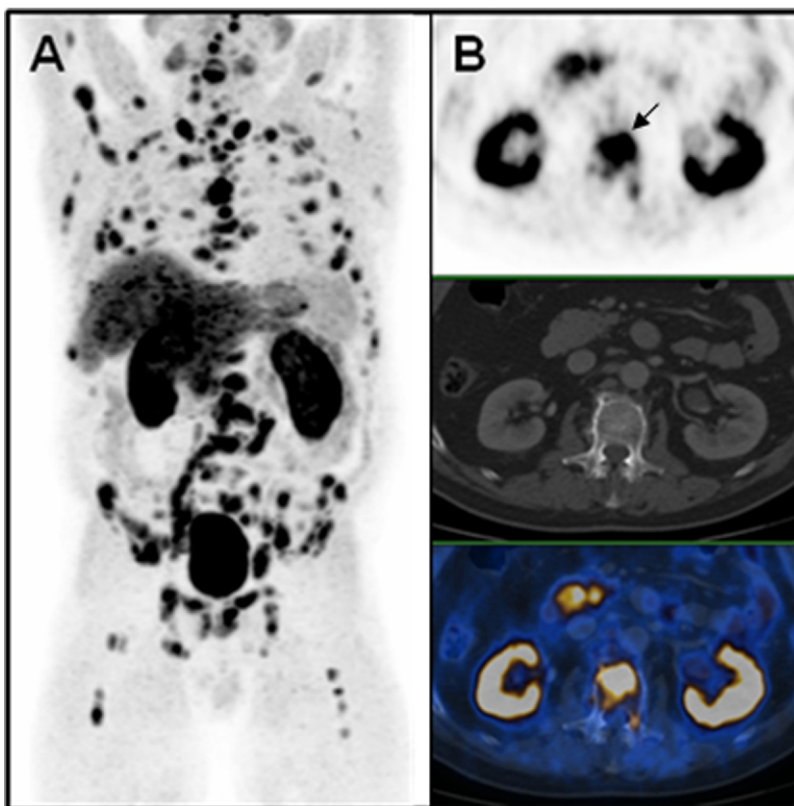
(A) Generalized BM detected by FCH PET/CT (MIP-Image) from a high-risk prostate cancer patient. (B) Transaxial images from a metastatic bone lesion in the thoracic spine (arrow).
